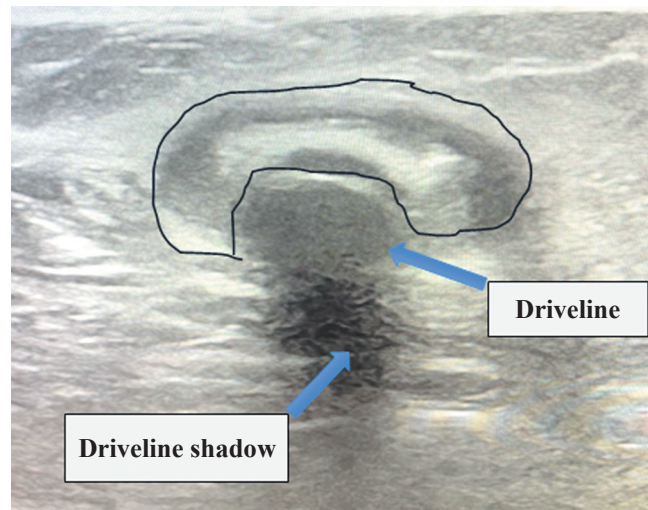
Ultrasound image demonstrating localized inflammation in the subcutaneous adipose tissue along the driveline of a long-term MCS system. The highlighted area shows a rounded anechoic formation with irregular, indistinct margins and hyperechoic inclusions, with a tissue thickness of up to 4–5 cm, consistent with inflammatory changes and fluid accumulation
